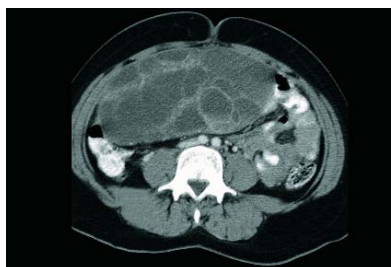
Granulosa cell tumour. Axial contrast-enhanced computed tomography image of the pelvis shows a large, well defined, multicystic mass.
